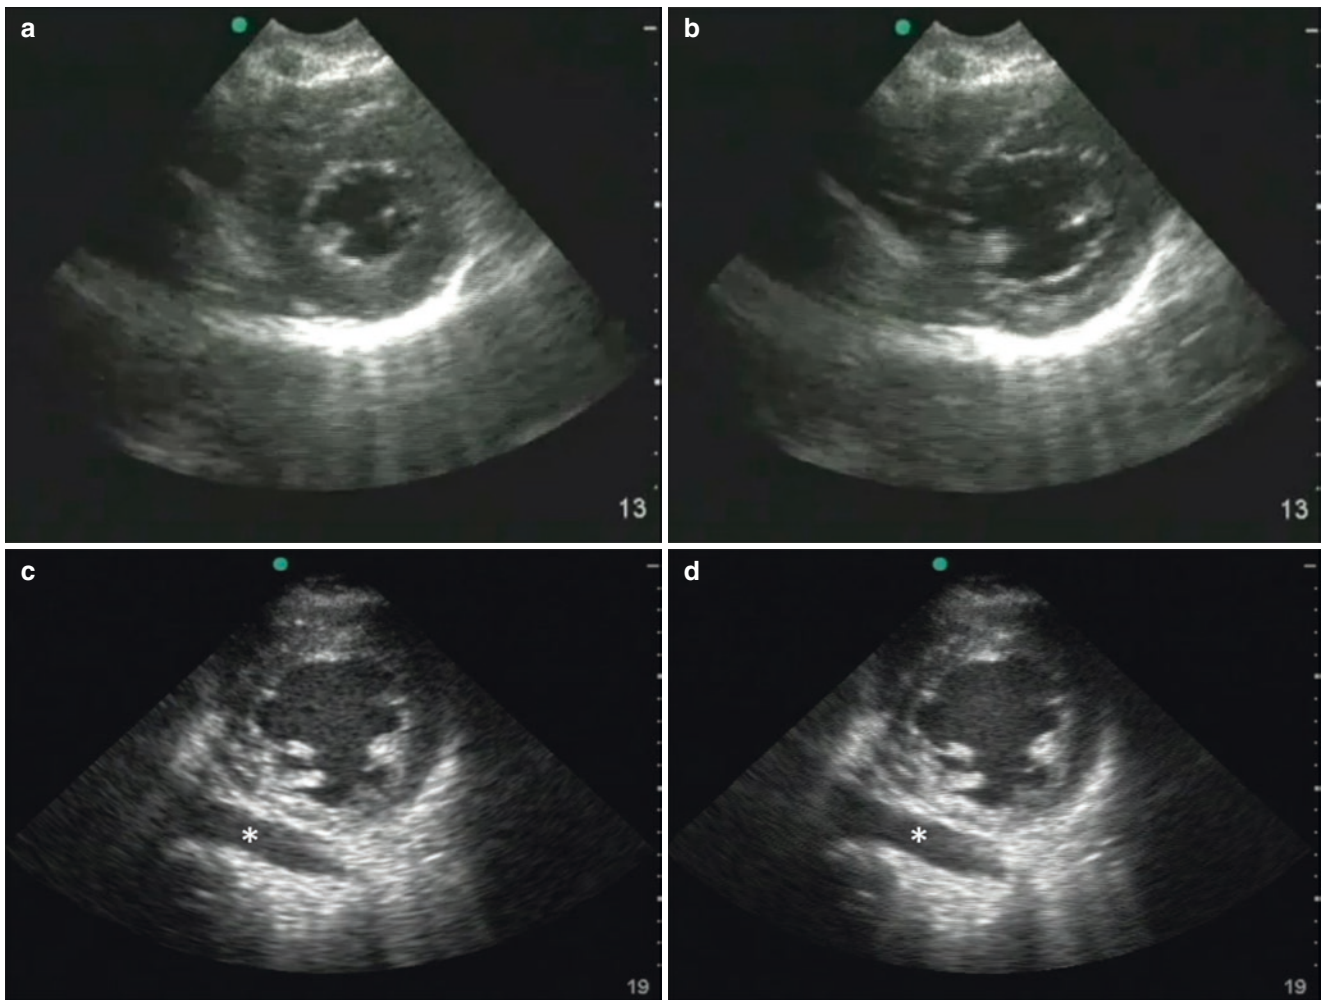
Left ventricular ejection fraction evaluated in the parasternal short axis. (a, b) End systole and end diastole in a normal heart. (c, d) End systole and end diastole, with markedly reduced wall contraction
